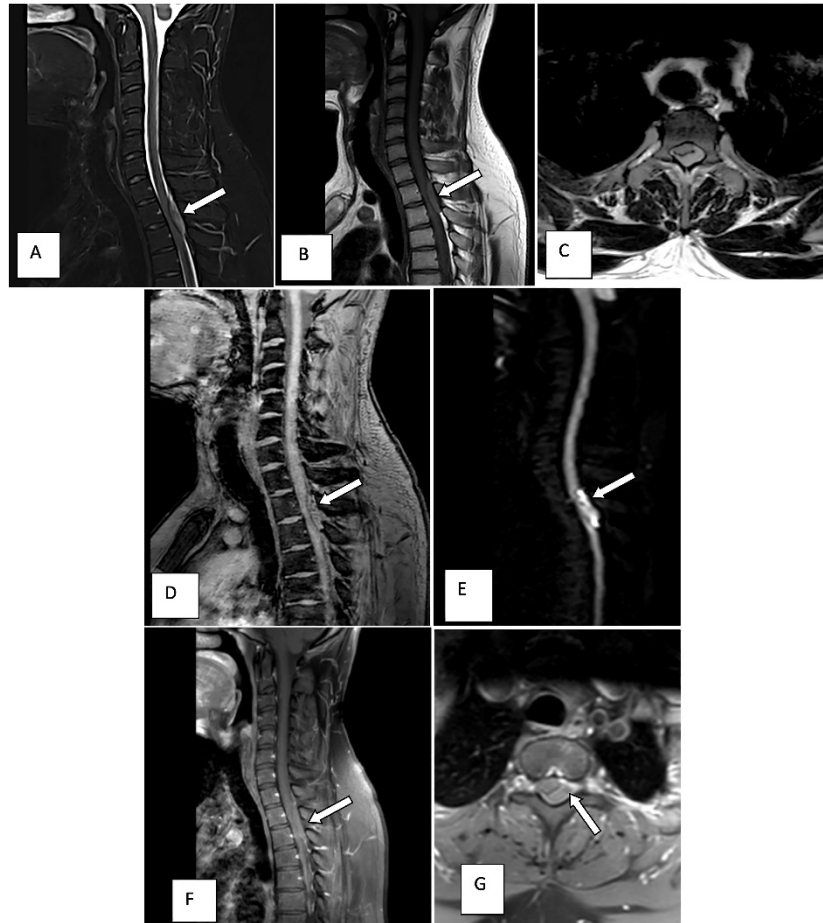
MR imaging repeated after 10 months for similar symptoms revealed an epidural lesion at D2-D3 level. T2W sagittal (A) and axial (C) images demonstrate an epidural hyperintense lesion at D2-D3 level, with interspersed hypointense areas (white arrows) causing mass effect on the cord. The lesion appears isointense on T1W sagittal (B) image (white arrow). Few susceptibility signals are seen within the lesion on SWI sequence (D, white arrow). The lesion displays restricted diffusion (E, white arrow). No evidence of any enhancement noted on post contrast images (F and G) as depicted by white arrows.
